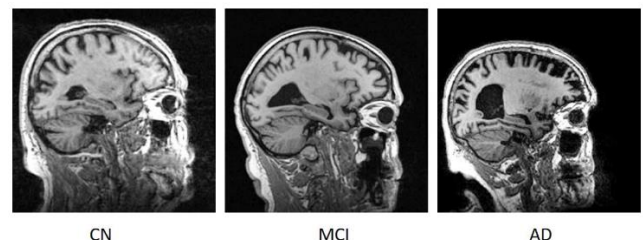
Sample brain MR image of a CN, MCI, and AD patient.
